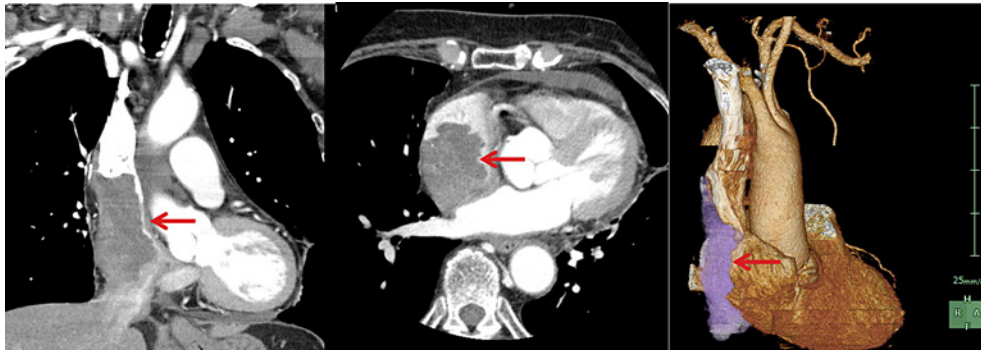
CT scan revealed that the low-density mass was located in the right atrium, narrowing the superior vena cava.
